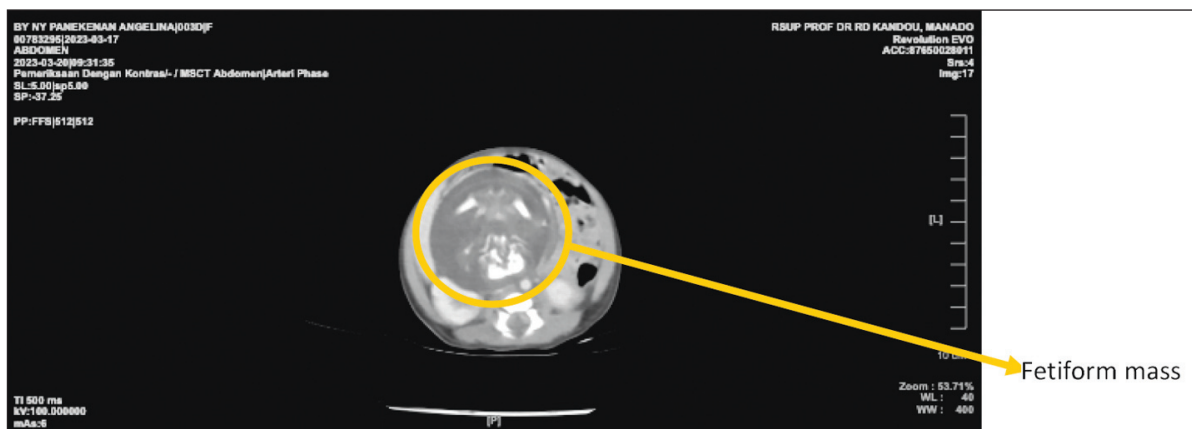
Multi-slice computed tomography findings (courtesy of author's documentation).
